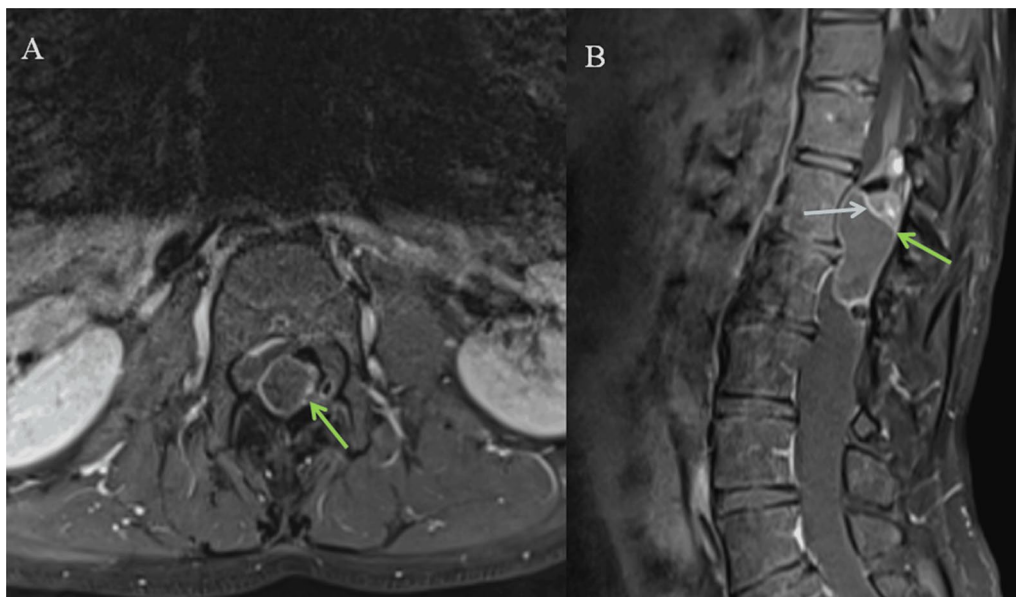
Enhanced MRI sequences of the lumbar spine showing the cauda equina mass. A Axial enhanced T1-weighted sequence after Gadolinium injection, exhibiting enhancement of the contours (green arrow) and septa (gray arrow) of the mass. B Sagittal enhanced T1-weighted sequence after Gadolinium injection, showing the peripheral enhancement of the mass (green arrow)
